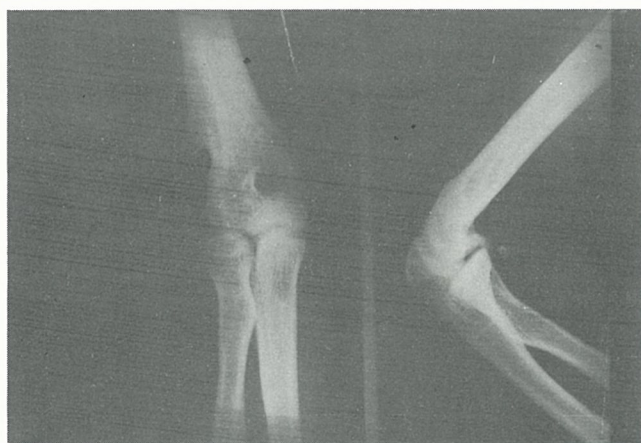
Final results of the patient with 132-month follow-up period (case 1); (a) anteroposterior and lateral views of roentgenograms of the right elbow and (b, c) the patient demonstrating a push-up exercise.
